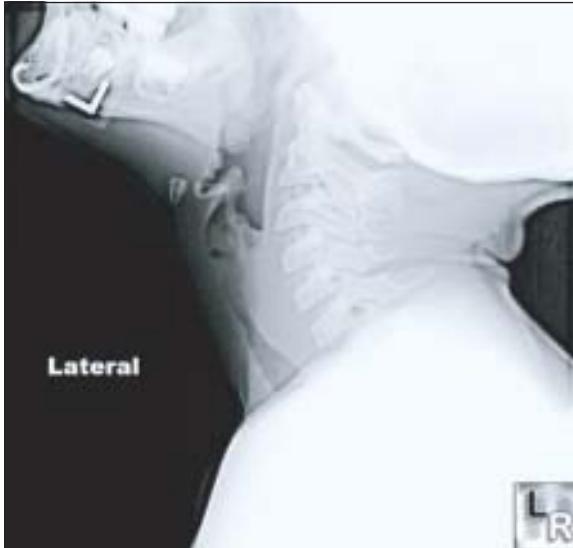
X-ray soft tissue neck showing normal epiglottitis.
